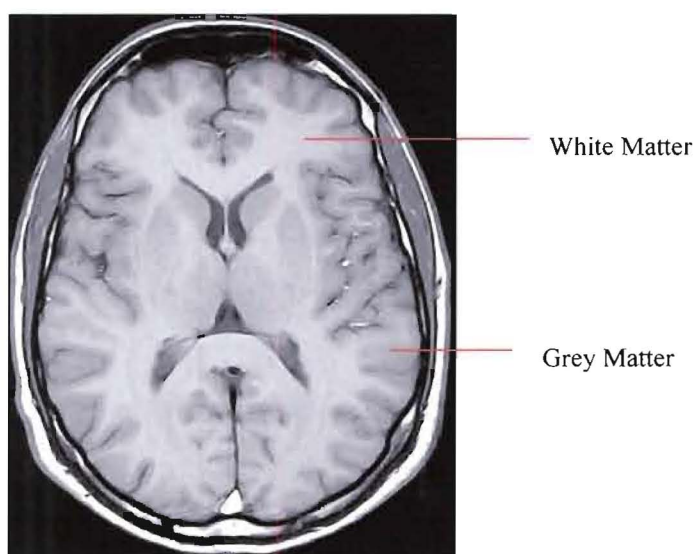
MRI image of a normal brain
